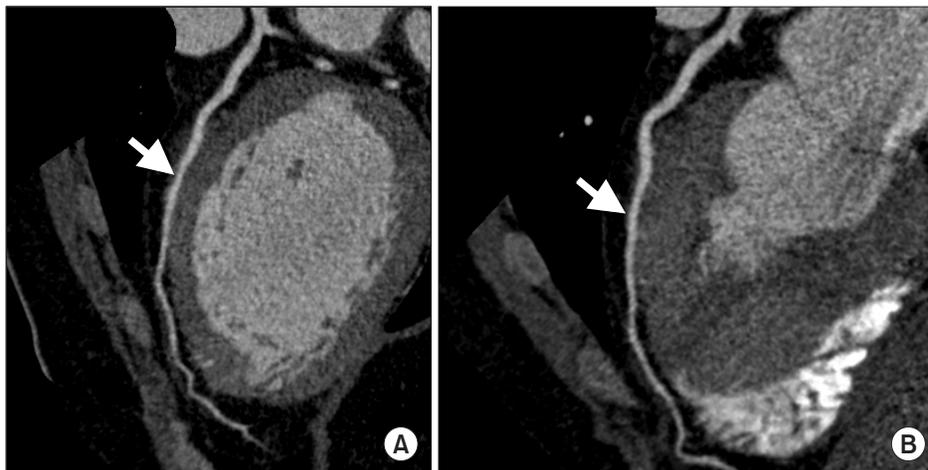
Coronary CT angiography reveals high-grade myocardial bridging (arrow) in the mid-segment of the left anterior descending coronary artery. (A) Coronal view, (B) axial view.
